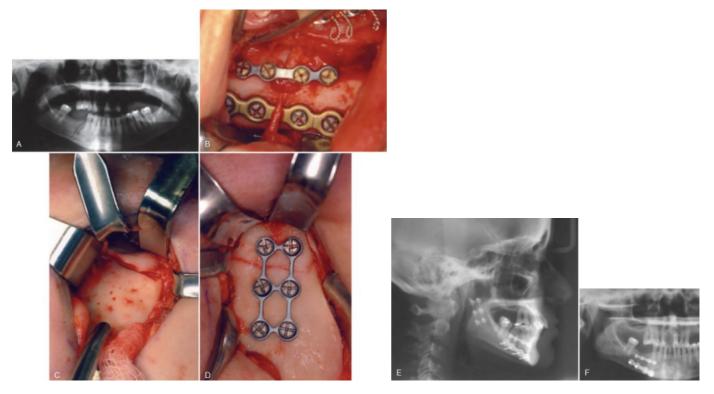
Right body and left subcondylar fracture of the mandible. A, Panoramic radiograph demonstrating a slightly oblique fracture of the right mandibular body with mild displacement and vertical overlap of the left subcondylar segmer inadequate dentition, particularly in the left posterior maxilla, to re-establish a proper vertical dimension through maxilomandibular fixation (MMF) alone. B, A transoral approach to the right body fracture was made after placing the patient in MI monocortical tension band, four-hole miniplate was applied above the mental neve, and a four-hole heavier fracture plate was applied at the inferior border, with the distal screws angled inferiority to avoid the inferior alveolar neve canal. C, Le submarkibular/retromandibular approach to the displaced subcondylar fracture. Note that the inferior edge of the proximal segment is laterally displaced. This is quite classic because the pull of the lateral progoid on the condylar head displamedially. When dissecting subperiostabily, this segment often falls underneath the dissection and must be palpated and retrieved from the superior flap. D, The reduced left subcondylar fracture, which was allowed to ingest a soft diet. E, A lateral displagram taken the first postoperative day shows good preservation of the posterior vertical dimension and projection of Panoramic radiograph demonstrating postoperative reduction and fixation of the right body and left subcondylar fractures.
